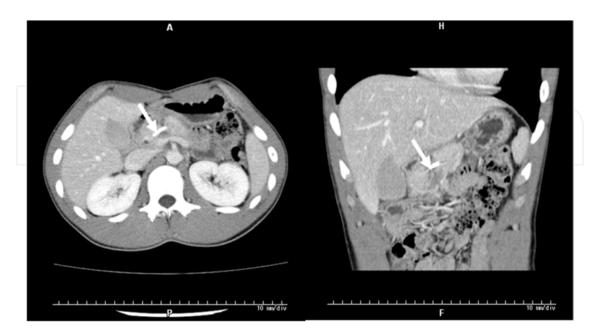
Enhanced CT revealed the inserted pancreatic stent and disappearance of pancreas peripheral fluid. (white arrow)
